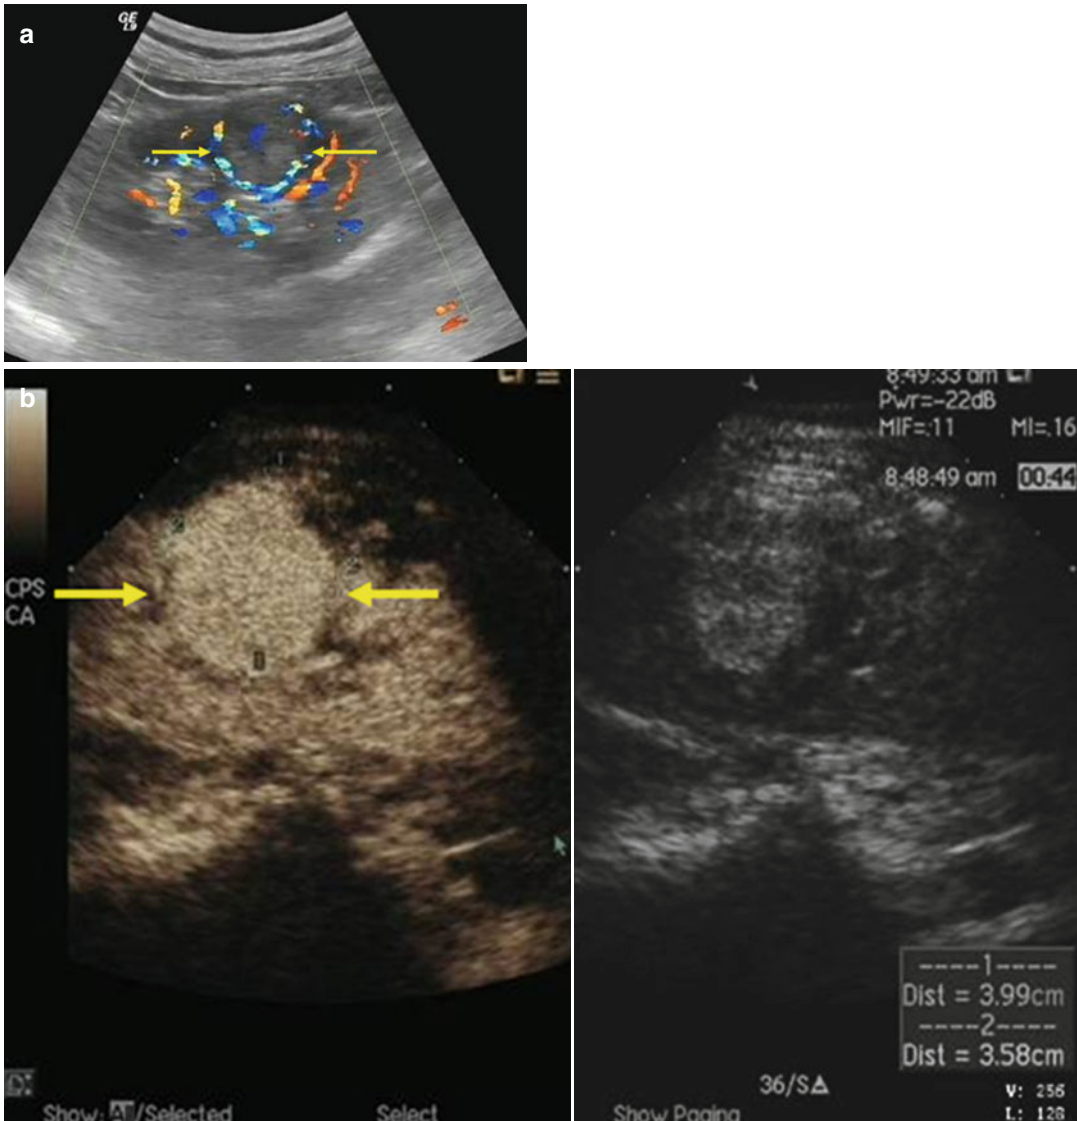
Microwave ablation (MWA) in an 87-year-old man with right renal cell carcinoma (RCC), who was unable to undergo nephrectomy because of coronary heart disease. (a) Preablation conventional ultrasound (US) scan shows a hypoechoic lesion with rich blood supply (arrows). (b) Contrast-enhanced US before MWA shows tumor enhancement in arterial phase with the size of 4.0×3.6 cm (mark). (c) Conventional US shows two
